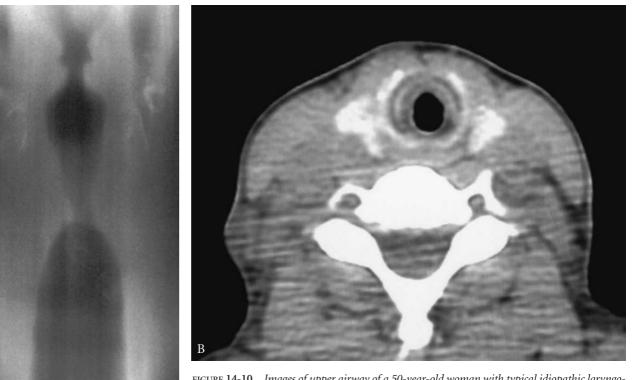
Images of upper airway of a 50-year-old woman with typical idiopathic laryngotracheal stenosis. A, Tomogram of the larynx and upper trachea. The false and true vocal cords are well outlined at the top. The stenosis involves the subglottic larynx and uppermost trachea. Compare with Figure. 14-9B. B, Computed tomography scan of the neck. The circumferential disposition of the stenosis lies within the ring of cricoid cartilage. Occasionally, the lesion is eccentric, although still circumferential.
